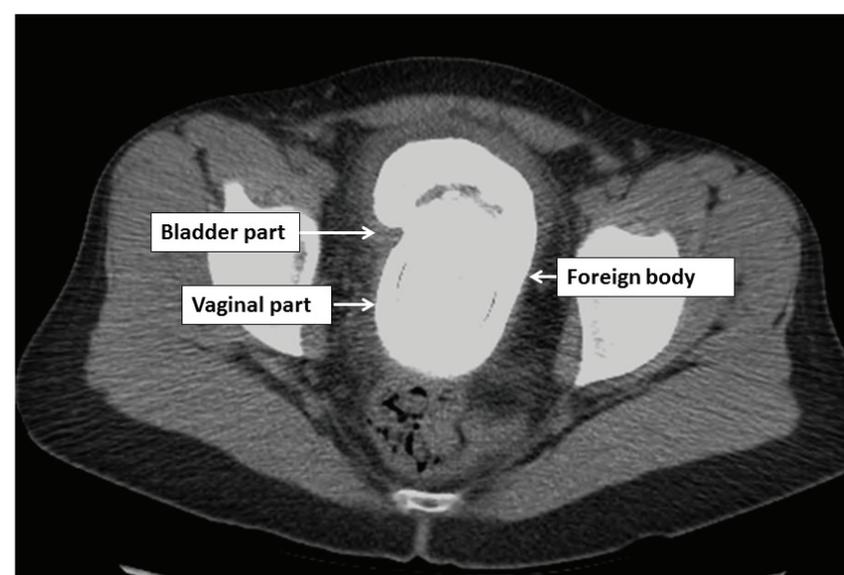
Cross section of CT of abdomen and pelvis demonstrates large calcific foreign body filling bladder and vaginal cavities.
